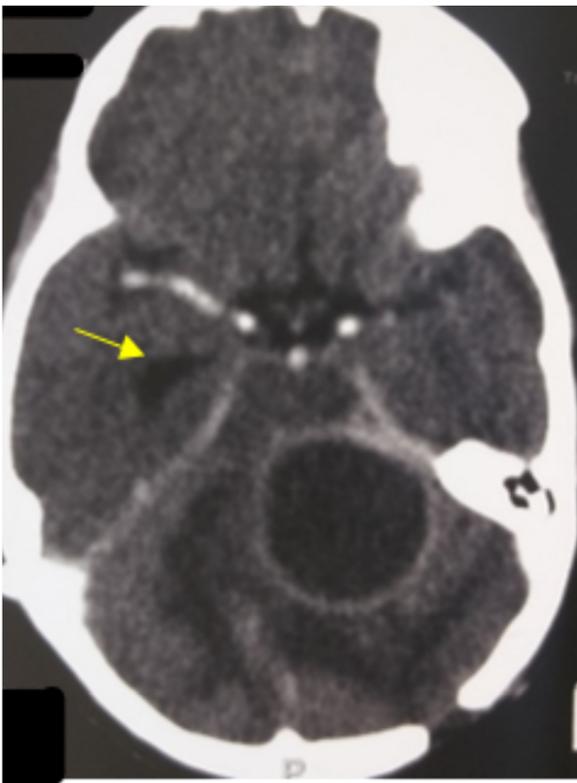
Brain CT scan showing recurrence of the cerebellar abscess and smaller ventricles after the shunt (yellow arrow).
